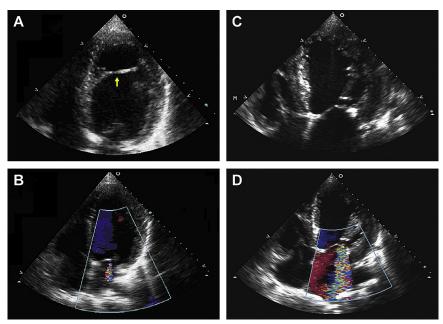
Echocardiographic images from two patients with dilated cardiomyopathy (LV ejection fraction <30%). The images in (A) and (B), from a patient with a transverse midcavity false tendon (*arrow*), reveal mild MR and a coaptation depth of 0.9 cm. By contrast, the images in (C) and (D), from a patient without a transverse midcavity false tendon, reveal severe MR and a coaptation depth of 1.8 cm. Reproduced with permission from Bhatt *et al.*²
